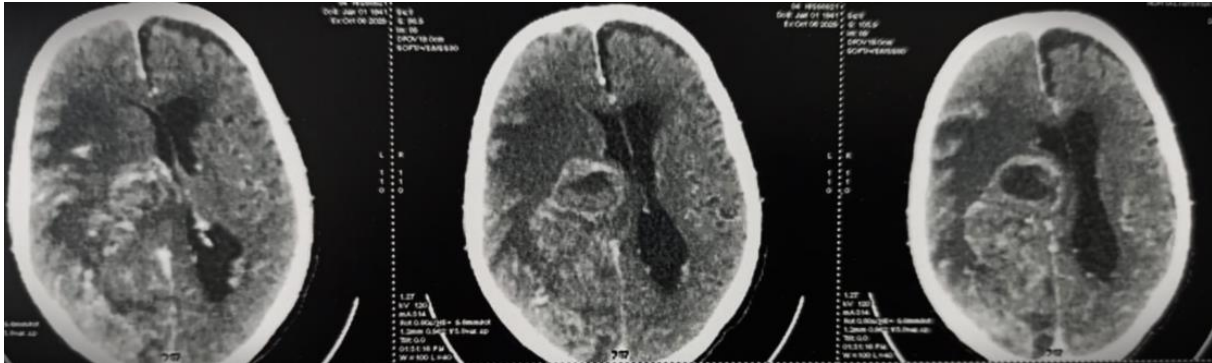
A CT scan showing evidence of supratentorial and infratentorial brain lesions, the largest of which is in the right parietal lobe with edema and subfalcine herniation.
